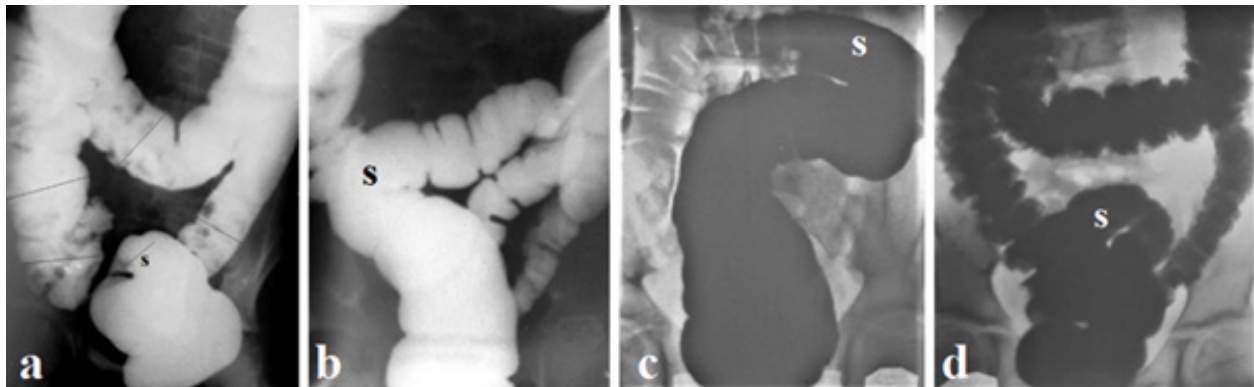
Frontal radiographs during the barium enema.
